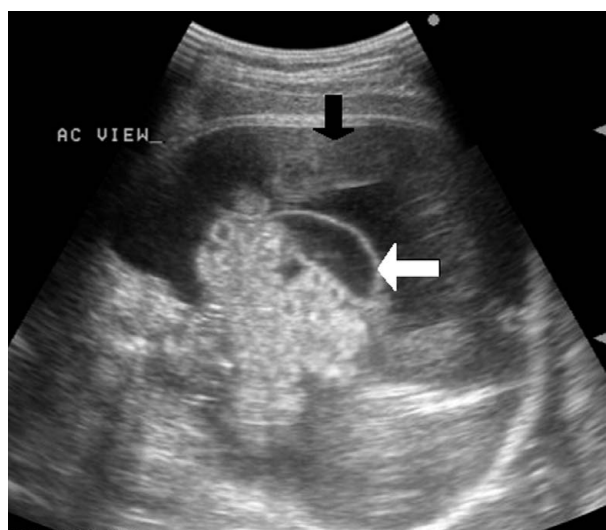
Massive ascites is the most common ultrasound finding in meconium peritonitis (black arrow). Dilated loops of intestine (white arrow) are indicative of intestine obstruction.
